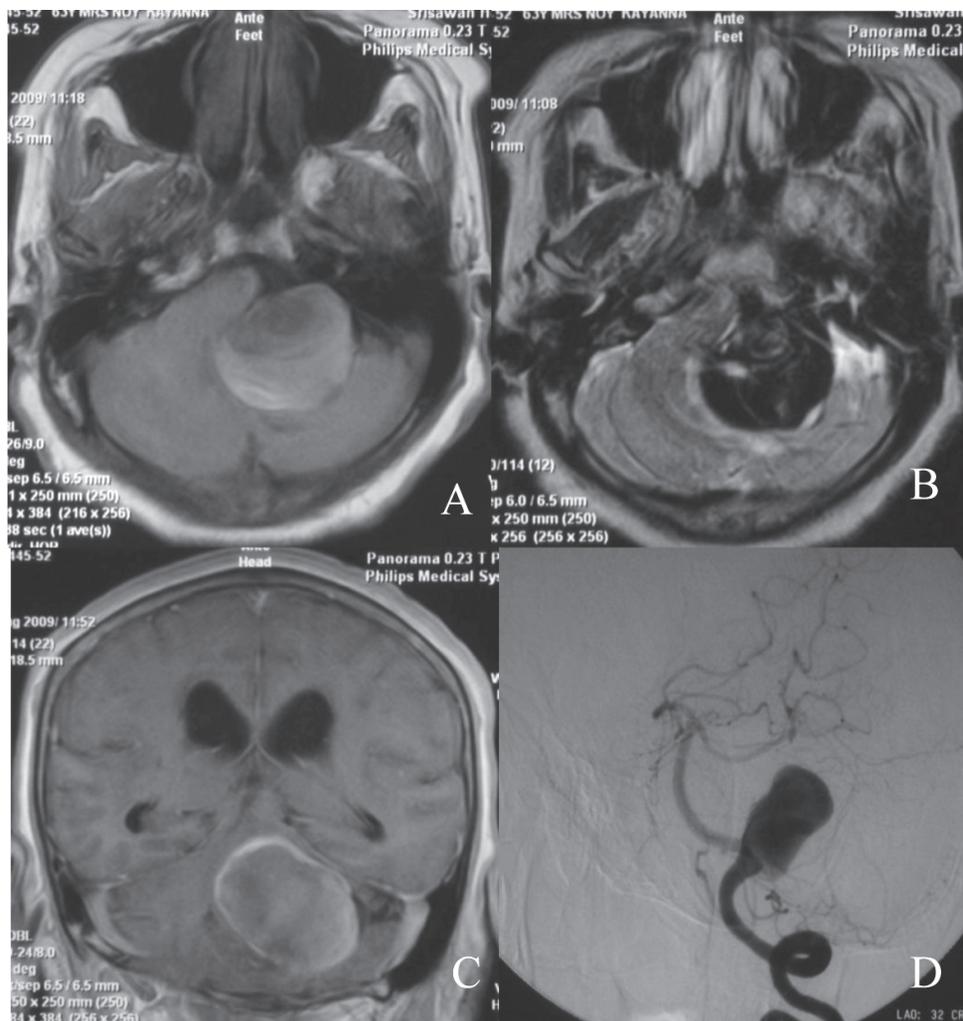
A 63-year-old female (case NO.10) presented with Lt. leg weakness. MRI (A,B,C) revealed a partially thrombosed giant aneurysm at Lt. CP angle region. DSA showed a saccular giant aneurysm at PICA segment of Lt. VA (D).
